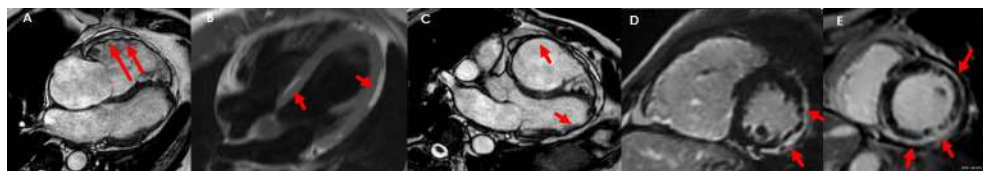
CMR findings in a patient with ACM. (A) RV aneurysms (arrows) in cine images. (B) Fibrofatty infiltration in T1-weighted turbo spin-echo sequences (arrow). (C) Right ventricular enlargement and left ventricular wall thinning (subepicardial fatty infiltration) (arrows) in a 3-chamber view cine. (D) Subepicardial LGE (arrows) and (E) subepicardial annular (arrows) patterns.
